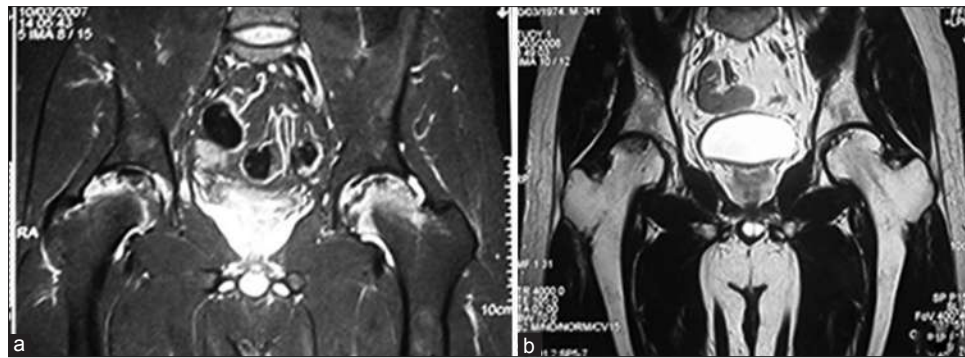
Magnetic resonance imaging of the same patient demonstrates edema inside femoral head as well as effusion in the hip joint (a-preoperative) and, after 1-year of core decompression the lesion has diminished in size, the edema has subsided and hip joint effusion is resolved (b-postoperative 1-year)
